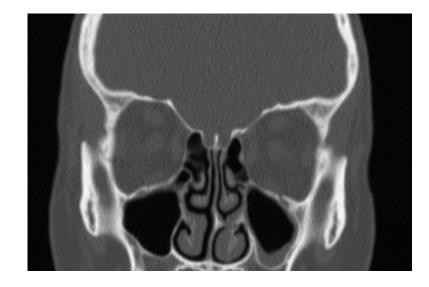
Non-contrast CT sinus showing an area of nasal obstruction. Left septal spur impinging an enlarged inferior turbinate with mild mucosal thickening of the left maxillary sinus
